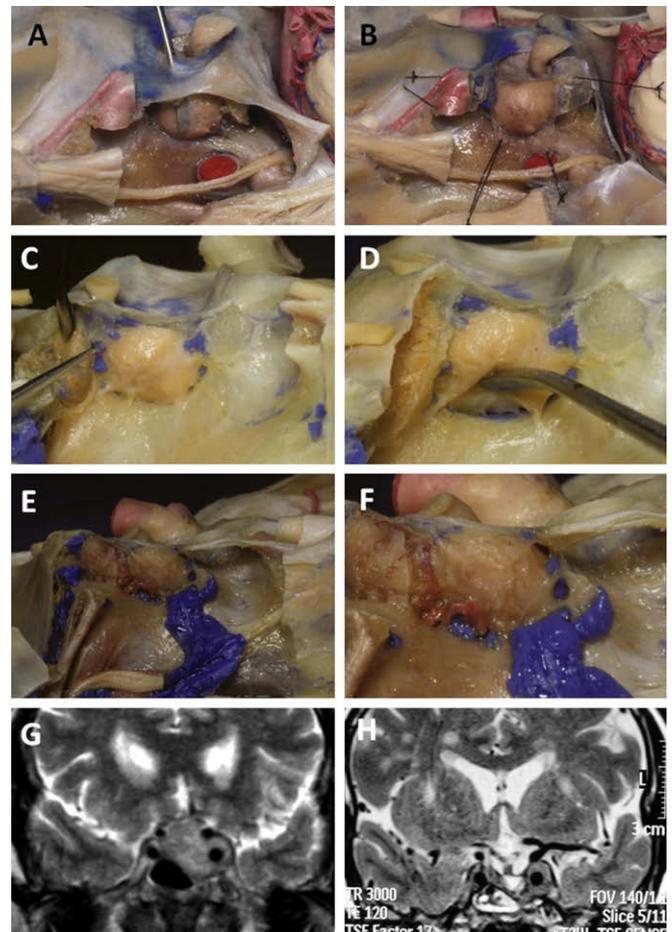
(A–F) Photographs of the medial wall of the cavernous sinus (CS) showing: (A) a microdissector placed between the pituitary gland and the medial wall of the CS; (B) the opened medial wall of the CS (sellar part); (C) the medial wall of the CS; (D) a microdissector elevating the pituitary gland; and (E) the medial wall of the CS, enlarged in (F). (G) Preoperative coronal T2-weighted MRI showing a pituitary macroadenoma with extension into the left CS; and (H) postoperative coronal T2-weighted MRI, after an endonasal trans-sphenoidal approach, showing tumor resection up to the medial wall of the left CS.
